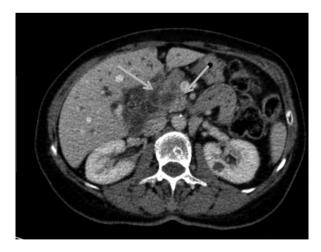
Computed tomography, 30.12.2016: tumour of the head of pancreas ($\uparrow\uparrow$), dilated bile ducts
